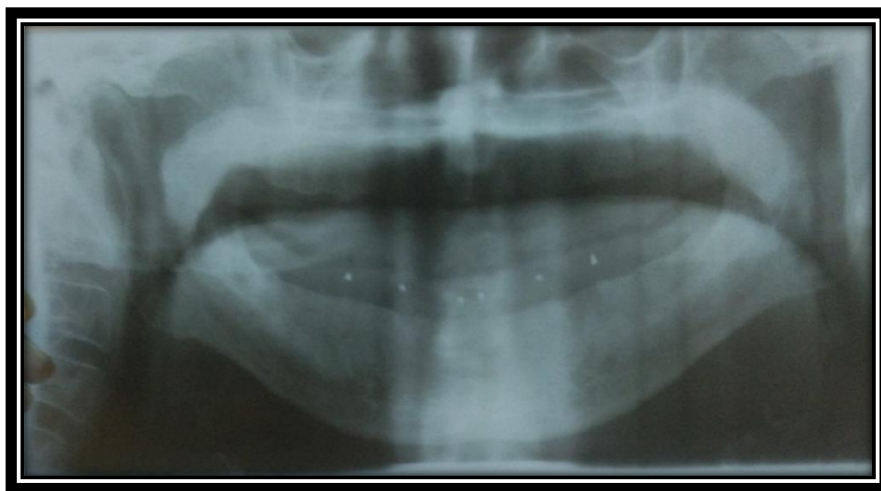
Orthopantomogram showing the position of radiopaque markers in mandibular denture.
